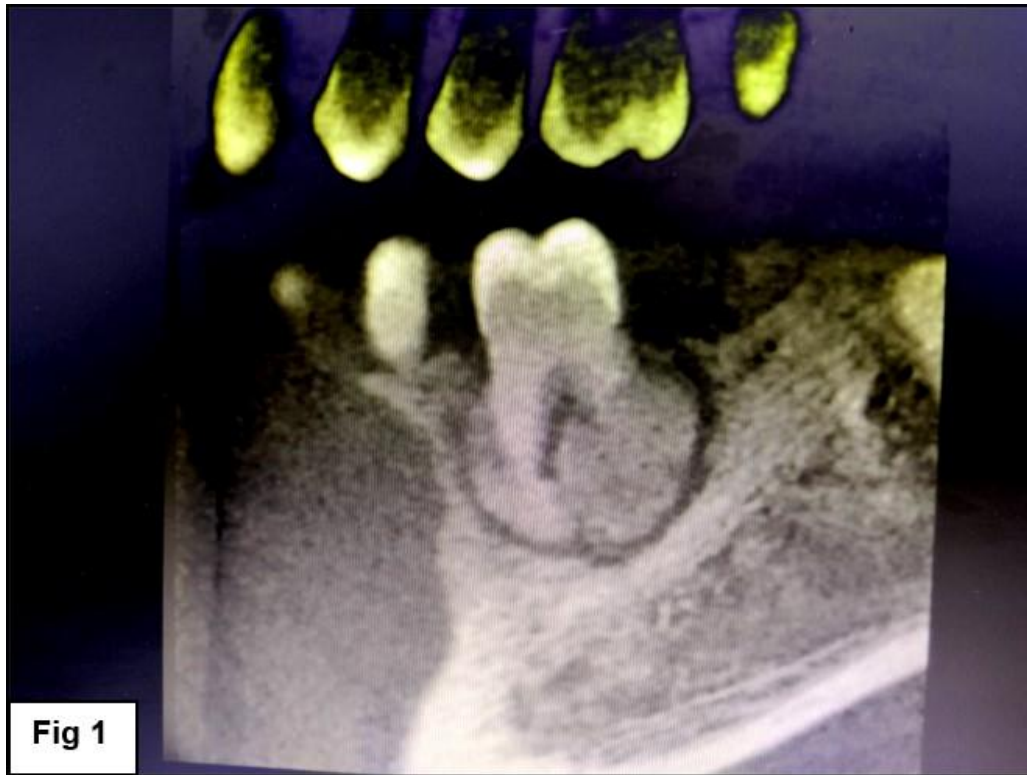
Radiograph showing well defined radio-opacity surrounded by radiolucent line involving the left mandibular first molar.
